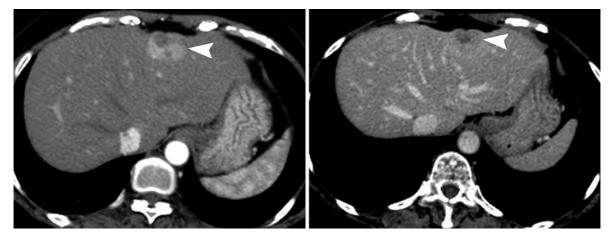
Small HCC showing heterogeneous arterial hyperenhancement. a Arterial phase CT scan shows a heterogeneously
